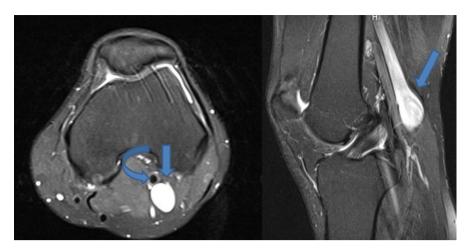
Axial and sagittal fat suppressed proton density MRI images demonstrates left popliteal aneurysm (arrows) posterior to popliteal artery (curved arrow).
